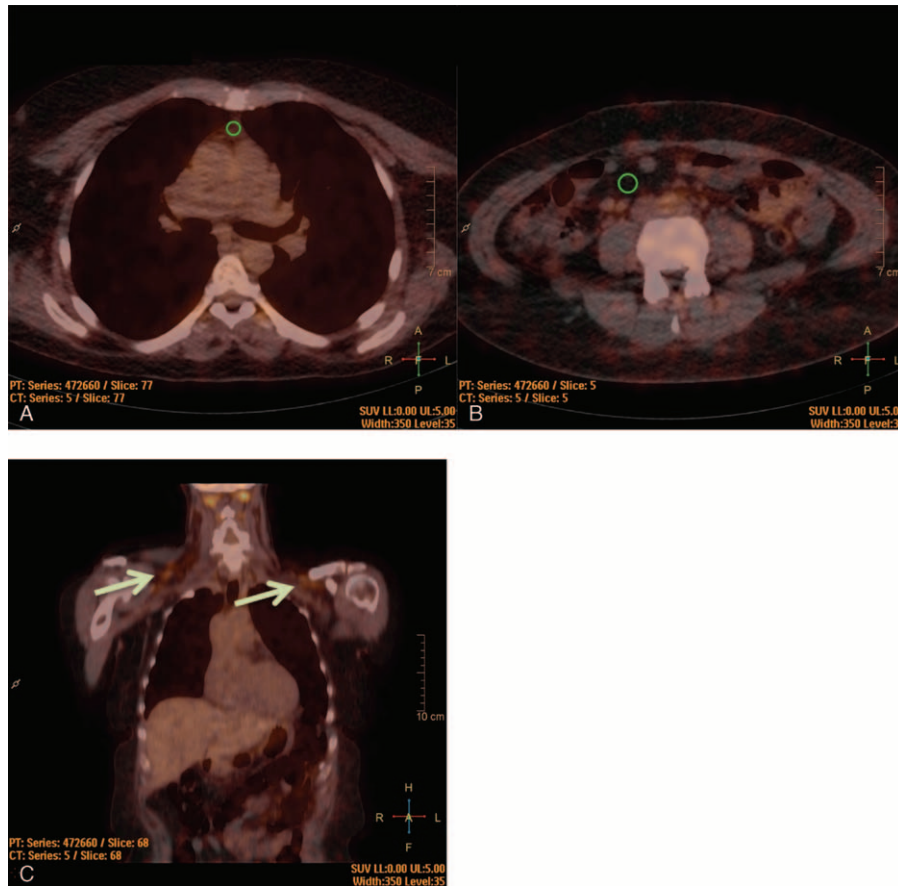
^{18}F -FDG PET/CT image analysis of the (A) PAT, the (B) VAT, and (C) BAT. For PAT and VAT, standard ROIs (green) were placed on 3 consecutive slices whenever possible and SUV_{max} values across those slices were averaged. Afterward, $\text{meanSUV}_{\text{max}}$ values were corrected for the ^{18}F -FDG uptake blood pool activity in the JVs to derive mean TBR ($\text{meanTBR}_{\text{max}}$) of the ^{18}F -FDG uptake. PAT ROIs were placed in the substernal mediastinal region of the chest cranial of the heart to avoid an ^{18}F -FDG overspill from the myocardium or the thoracic vasculature. For VAT analysis, ROIs were placed in the abdominal visceral fat tissue above or below the kidneys to avoid overspill from the physiological ^{18}F -FDG uptake in the kidneys. (C) Typical localization of BAT in the shoulders (arrows) 1 year after BaS. In this patient, no BAT at all was observed before BaS (image not shown). As with PAT and VAT, SUV_{max} values of BAT were afterward corrected for blood pool activity in the JV to derive TBR_{max} values. ^{18}F -FDG = ^{18}F -fluorodeoxyglucose, BaS = bariatric surgery, BAT = brown adipose tissue, JV = jugular vein, PAT = pericardial adipose tissue, PET/CT = positron emission tomography/computed tomography, ROI = region of interest, SUV_{max} = maximal standardized uptake value, TBR = target-to-background ratio, VAT = visceral adipose tissue.
